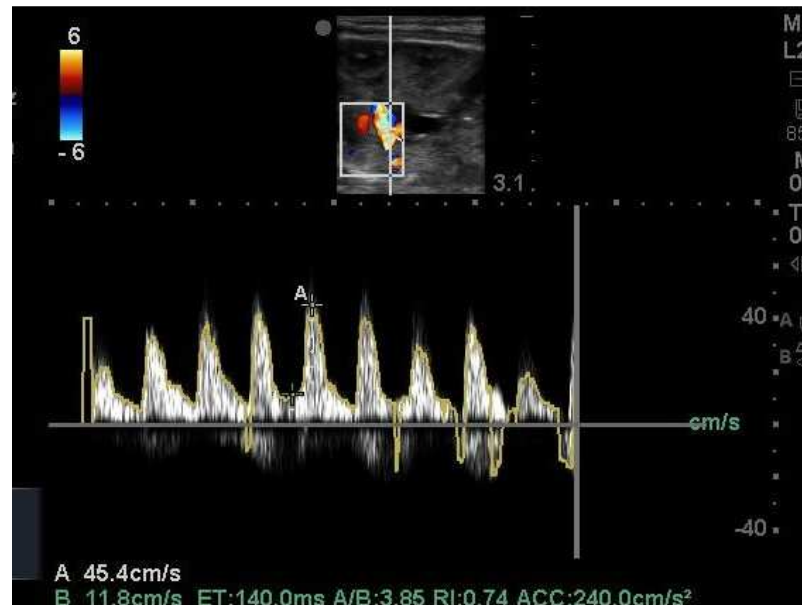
Improved doppler in left renal artery.
